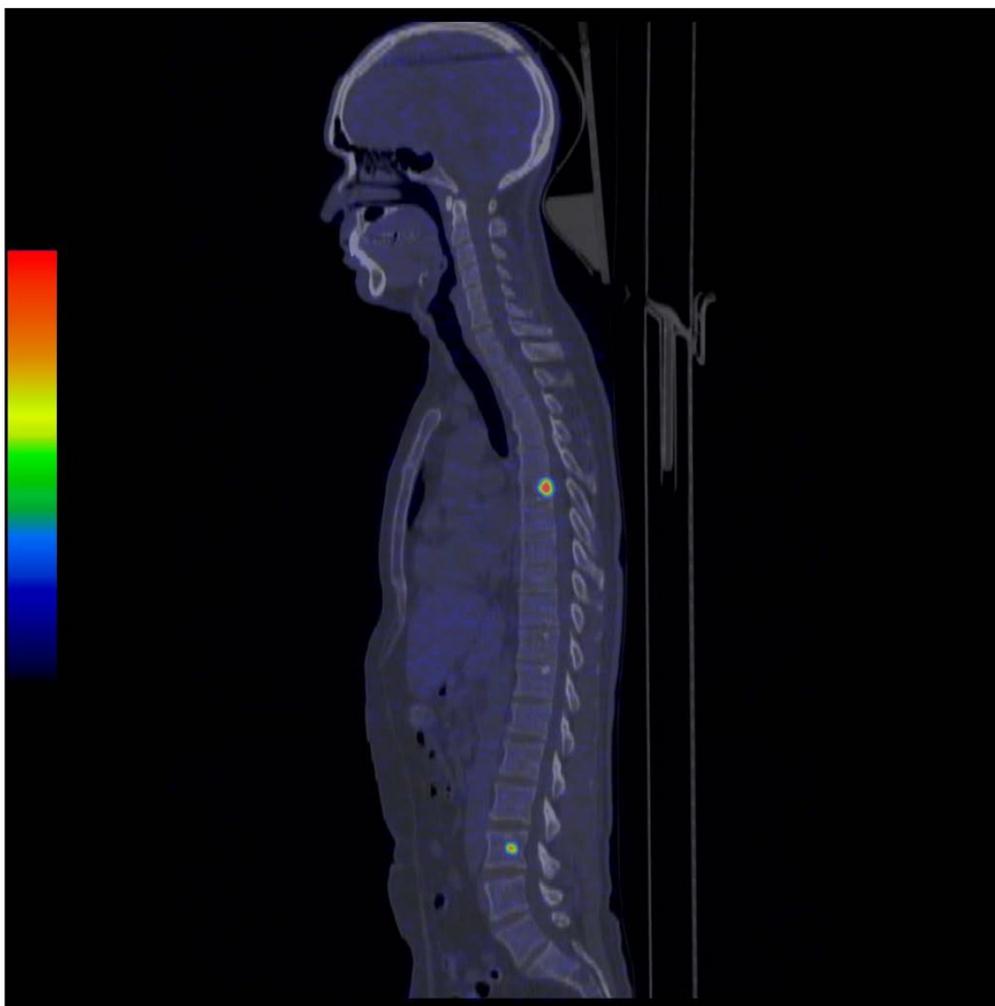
A sagittal [^{11}C]-5-Hydroxytryptophan PET/CT sectioning the spine in a patient referred for follow-up after treatment for a carcinoid tumor. Because of the specificity of the tracer, the very intense uptake in the millimeter-sized spinal lesions is highly suspicious for bone metastasis.
